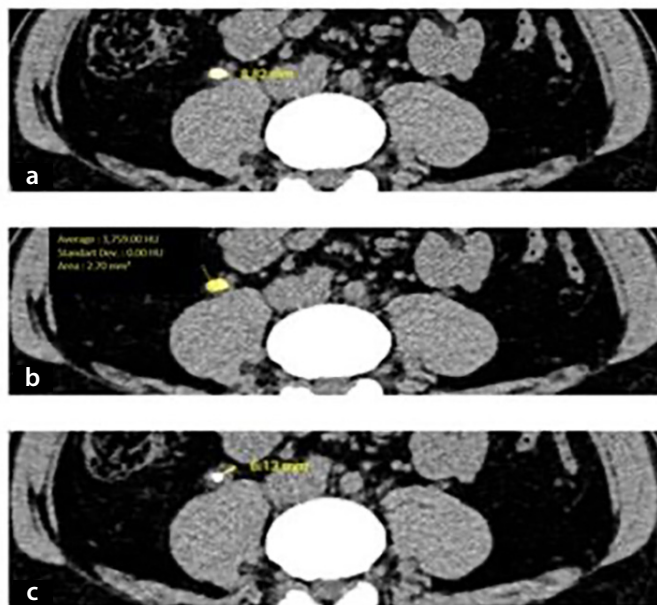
Non-contrast axial plane CT images: the diameter (a) and density (b) of the ureteral stone are measured at a single level where the stone's diameter is widest. Ureteral wall thickness (c) is measured at the level where the soft tissue density, consisting of the ureter wall and periureteral edema surrounding the stone, is highest, using the freehand ROI option. CT, computed tomography; ROI, region of interest.
